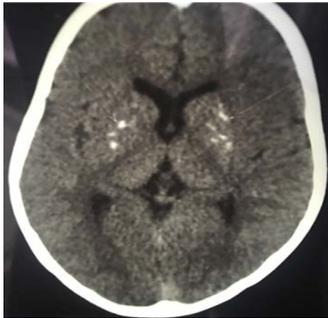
Brain CT scan at the age of 2 years shows the calcification of basal ganglia (specially globus pallidus and putamen), arrows present calcification area.
